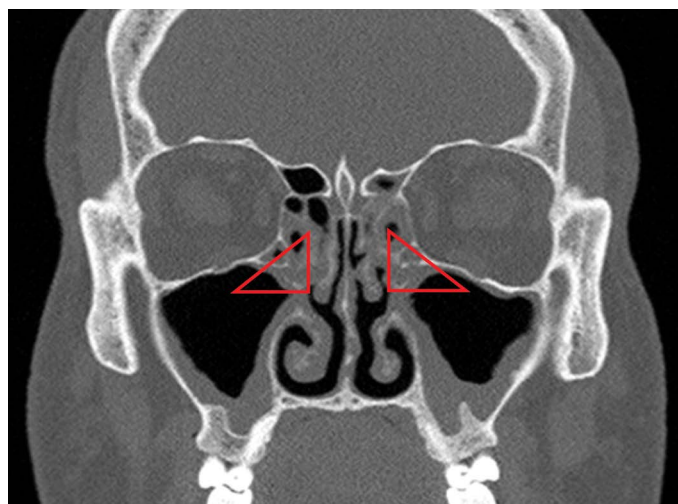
CT scan of paranasal sinuses in frontal projection of patient with bilaterally obstructed ostiomeatal complex (marked with a red triangle). Mucosal thickening in the maxillary and ethmoid sinuses.
